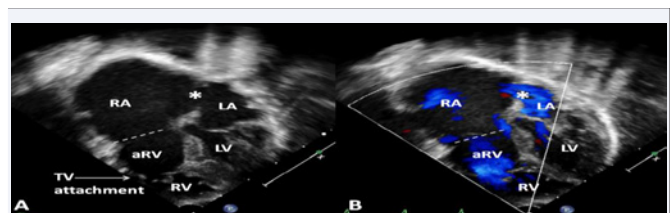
An echocardiogram of a neonate with Ebstein's anomaly. Apical four-chamber views are shown. A shows a two-dimensional image. B shows the same image with color Doppler flow mapping. Note the significant downward displacement of the tricuspid valve (TV) attachment (solid arrow labeled "TV attachment") from the true annulus of the tricuspid valve (marked by a dotted line). The portion of the right ventricle (RV) between the tricuspid valve true annulus and the tricuspid valve attachment is the atrialized portion of the right ventricle (aRV). * represents the location of the patent foramen ovale (PFO). The color Doppler image in B shows right-to-left shunting (blue color). Note the markedly enlarged right atrium (RA) in both A and B. LA, left atrium; LV, left ventricle. Reproduced from Reference [9].
